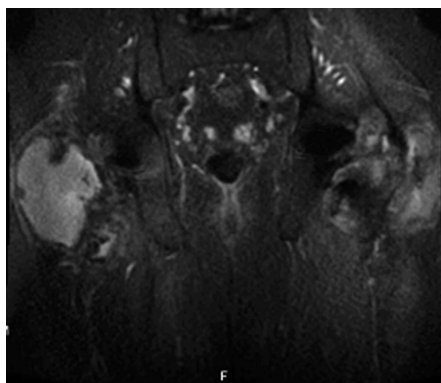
Metal artifact reduction magnetic resonance imaging (coronal view) showing the adverse reactions to metal debris and formation of pseudocapsules in both hips following bilateral total hip arthroplasties with modular necks.
